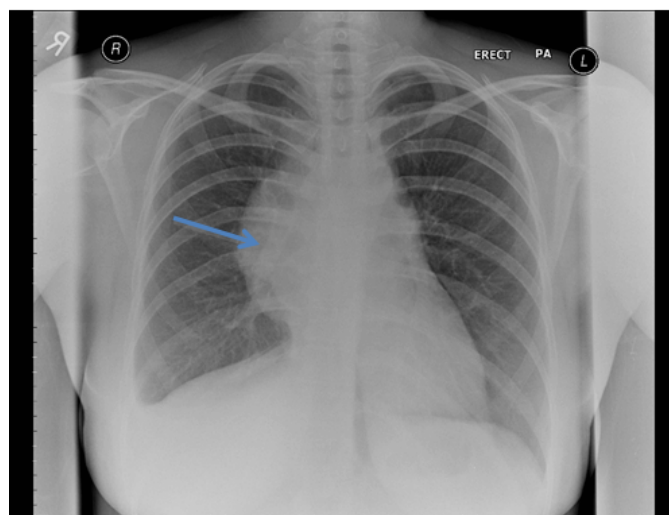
A chest X-ray showing widened mediastinum.
